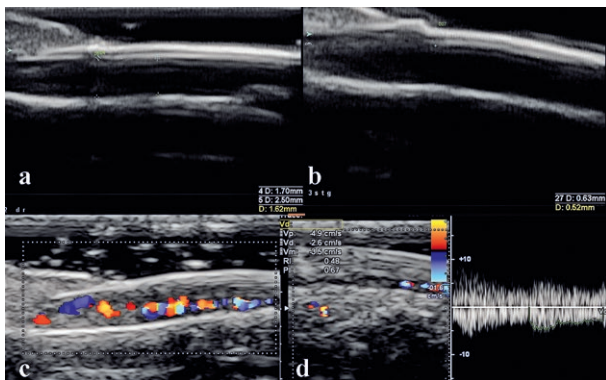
Normal US nail aspect in a non-affected 47 years old woman: a) 2D US – thickness of the nail bed; b) 2D US – measurement of the nail plaques thickness; c) color Doppler US – aspect of the vessels in the nail bed; d) spectral Doppler – measurement of the Doppler indices in nail vessels
